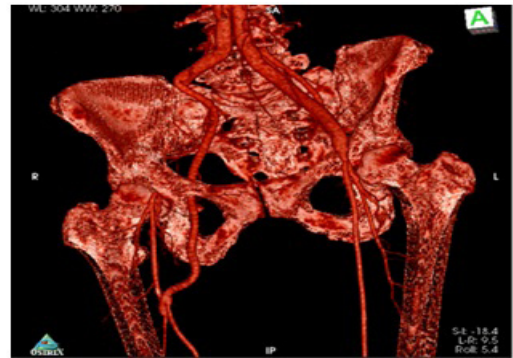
3D-Angio-CT reconstruction (antero-lateral view) showing the partial resection of the infected right branch of an aorto-bifemoral by-pass graft, and substitution by a new obturator foramen by-pass graft. Take note of the distal anastomosis at distal profunda femoral artery (far from infection) and the transposition of the superficial femoral artery on the distal graft anastomosis.
